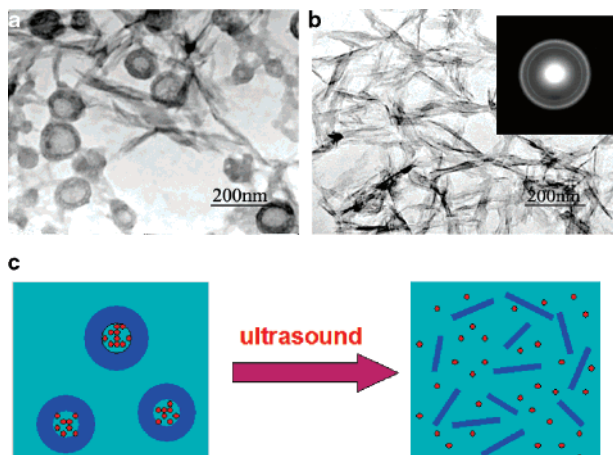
(a) TEM of an interim stage, the coexistence of original hollow spheres, and transferred pin-like crystallites (1 min of ultrasonic application); (b) TEM and SAED of the final stage (5 min ultrasonic application) of the transformation. (c) Scheme of a suggested drug release system.
